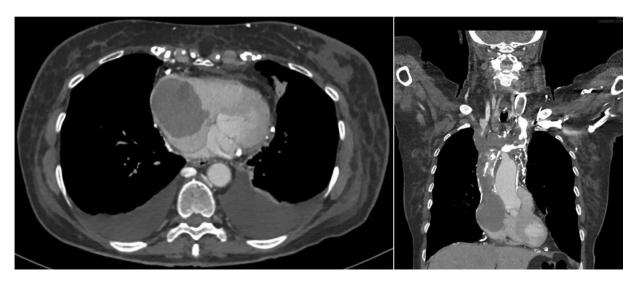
(A) Axial contrast-enhanced CT image shows a large filling defect in the right atrium. (B) Coronal contrast-enhanced CT image shows a massive irregularly filling defect involving the anonymous vein and superior vena cava.
